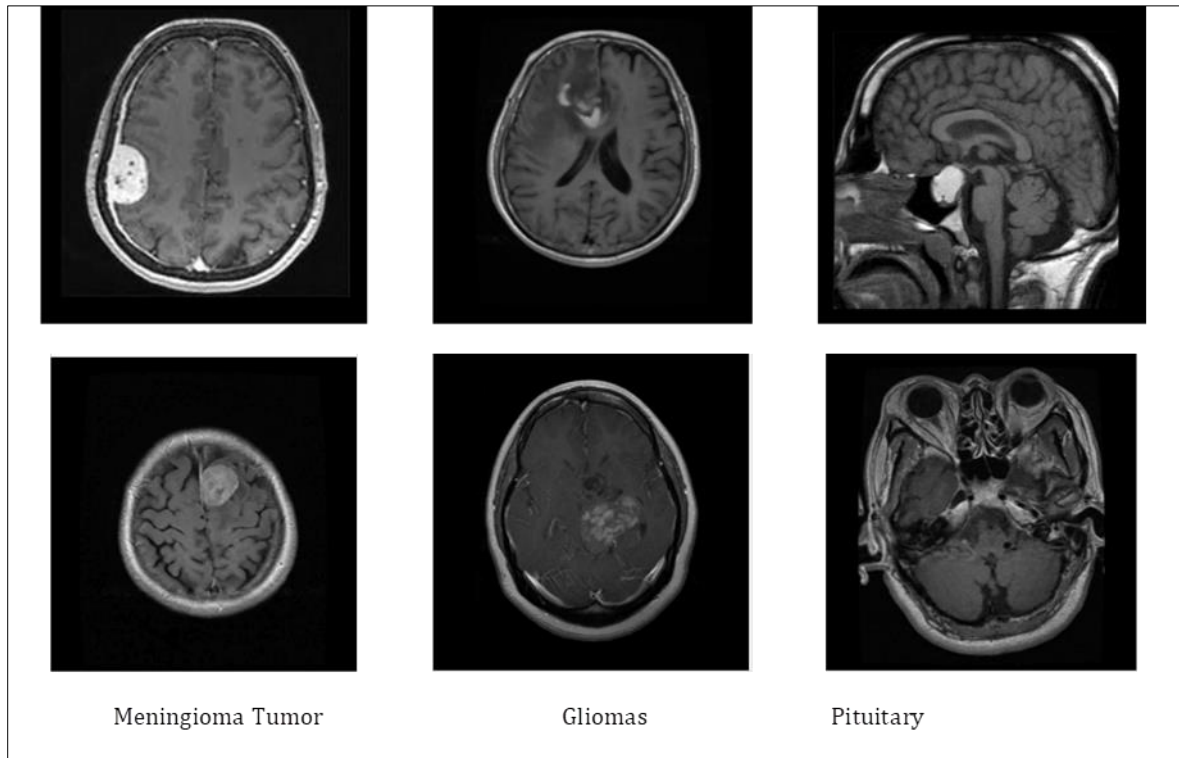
Some examples of MRI images for different types of Brian Tumors
